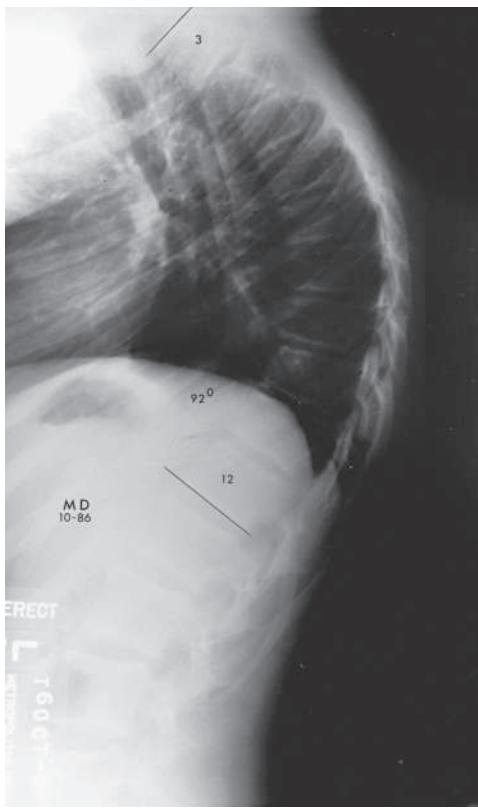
Standing lateral radiograph of a 14-yr-old boy with severe Scheuermann kyphosis. This measures 92 degrees between T3 and T12. Note the wedging of the vertebrae at T6, T7, T8, and T9. The normal thoracic kyphosis is ≤ 40 degrees.
